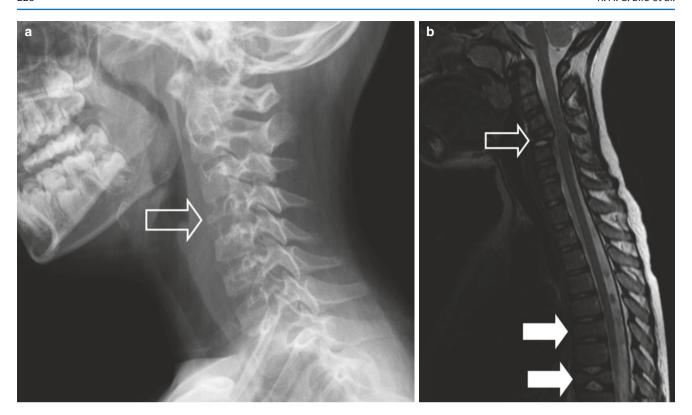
(a) Radiological examination for suspected child abuse. The cervical spine view shows anterolisthesis (>3 mm) and a defect in the arch of C2 (open arrow) (Reprinted from [76]. With permission). (b) CT of the cervical spine shows a sclerotic margin of the arch defects
